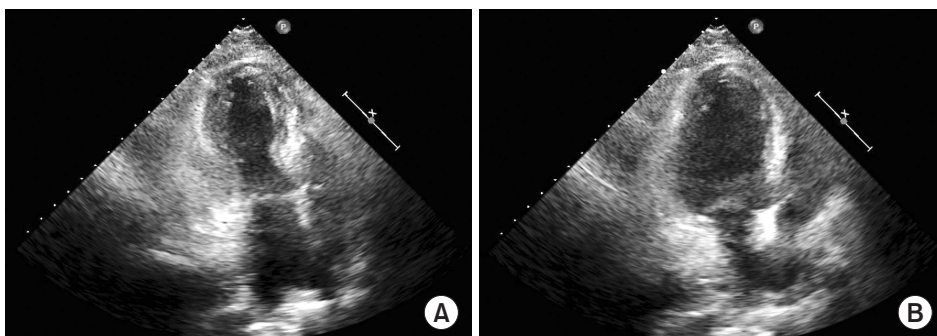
Echocardiography during systole (A) and diastole (B), on the first day of admission. Initial echocardiography reveals left ventricular apical wall motion abnormality and ballooning.
